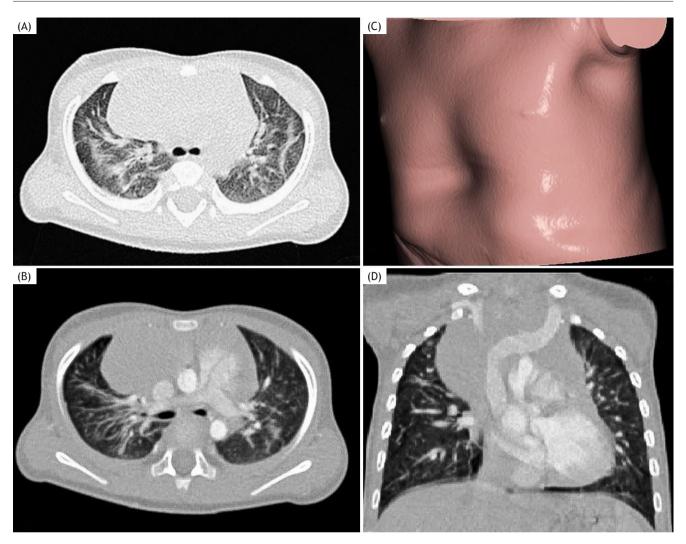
Thoracic HRCT imaging with contrast medium. (A) Axial view, pulmonary window. Bilateral fibrotic strands and mosaic perfusion in upper lobes of the lungs; (B) Axial view, pulmonary window. Fibrotic strands and mosaic perfusion in LS8 and LS9; (C) Volume rendered technique (VRT) showing chest deformity (pectus excavatum); (D) Coronal view. Chest deformity with modeling of the right atrium and right ventricle of the heart by a low part of the sternum.
